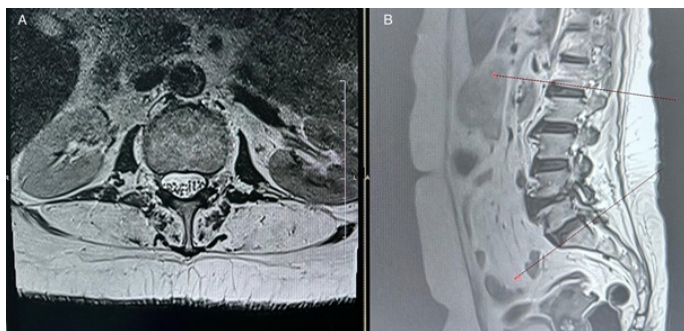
1 Lumbar MRI at L1 level (the level at which we apply the process), T2 sequence, axial (A) and sagittal (B) slices
